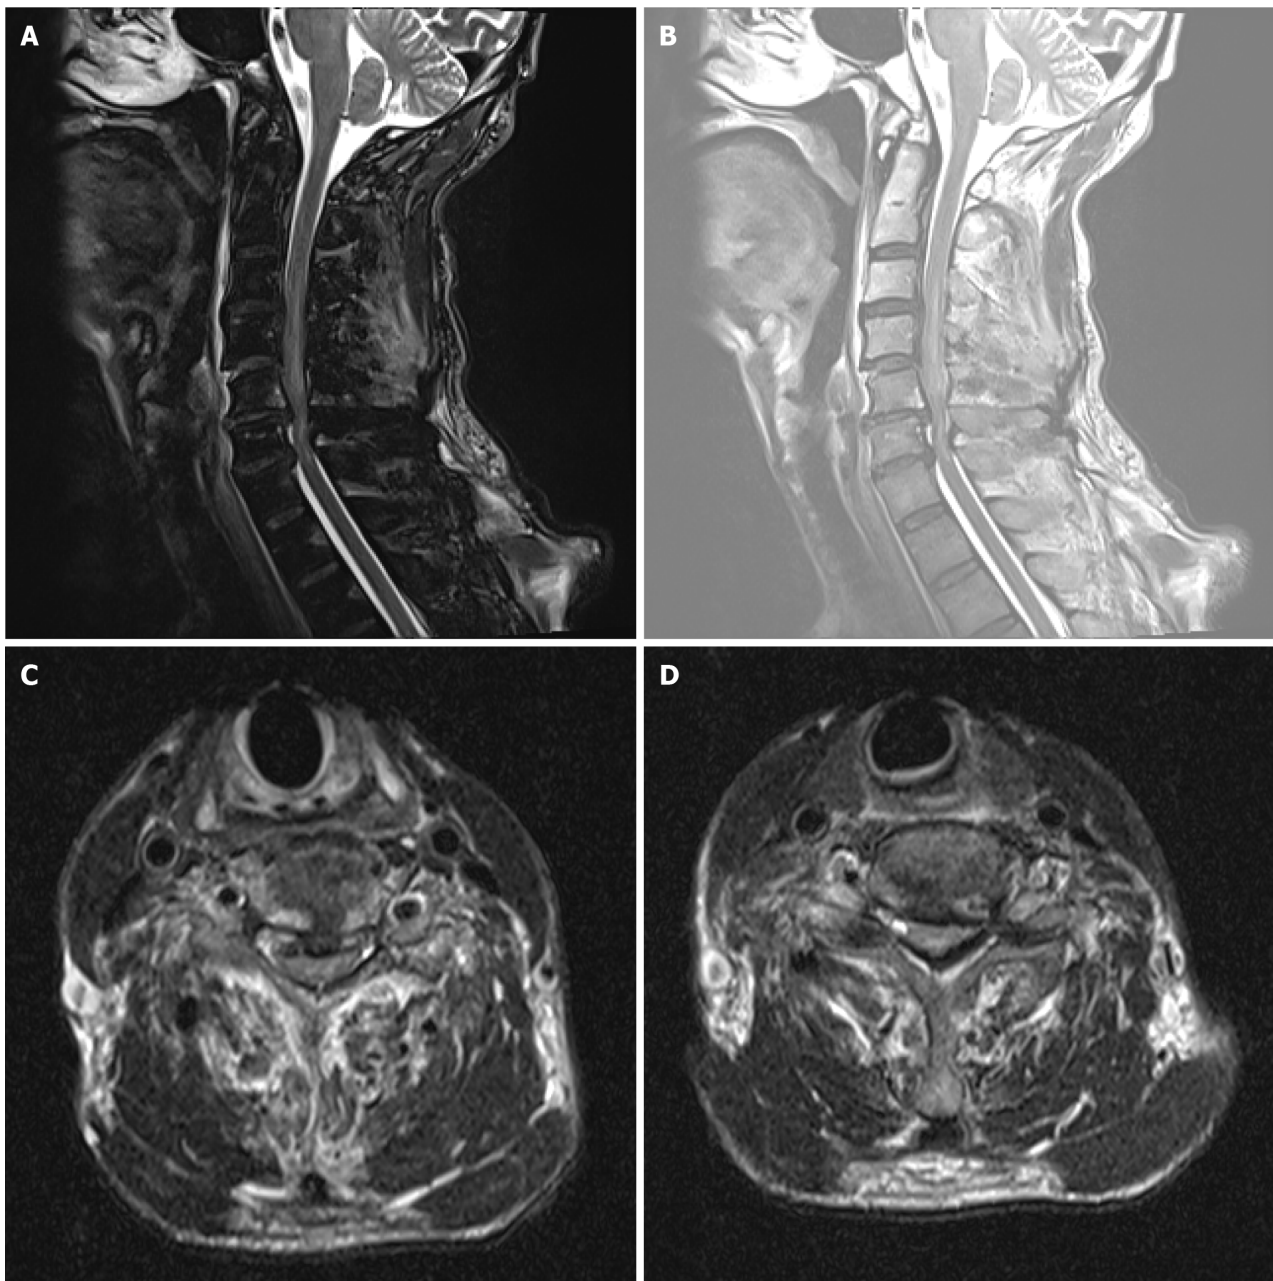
Preoperative magnetic resonance imaging image of the cervical spine showing C3-C7 spinal canal stenosis with spinal cord edema. A: Sagittal T2 weighted imaging (T2WI); B: Sagittal T2WI + fat suppression; C and D: Axial T2WI at the C5/6 (C) and C6/7 (D) levels showing traumatic disc rupture, protrusion and spinal cord compression.
